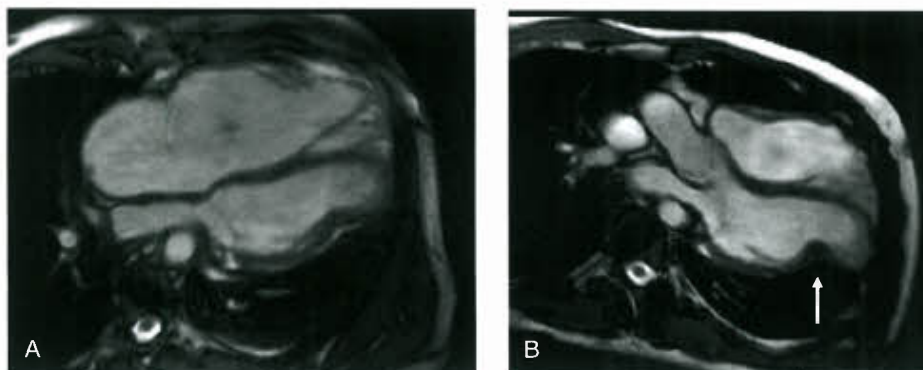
Cardiac MRI sequences in an adolescent patient demonstrating partial absence of the pericardium. Note the marked displacement of the heart into the left hemithorax. While the herniation of the apical LV wall is more subtle in this four-chamber view in systole (A), it becomes more apparent in the LV outflow-tract view in late diastole (B). (Courtesy of Dr. Malek El-Yaman, West Virginia University Children's Hospital, Morgantown, WV.)
